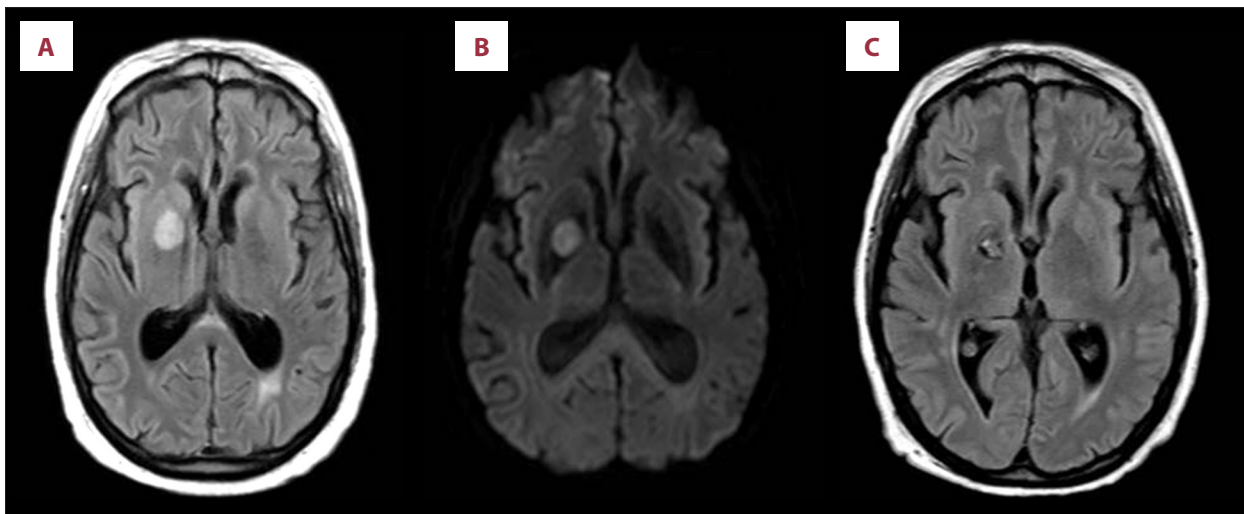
MRI of the brain: (A) Hyperintense lesion in the right basal ganglia before treatment (FLAIR). (B) Diffusion-weighted image showing a restricted diffusion lesion. (C) Resolved lesion with residual gliosis 9 months after treatment (FLAIR).
